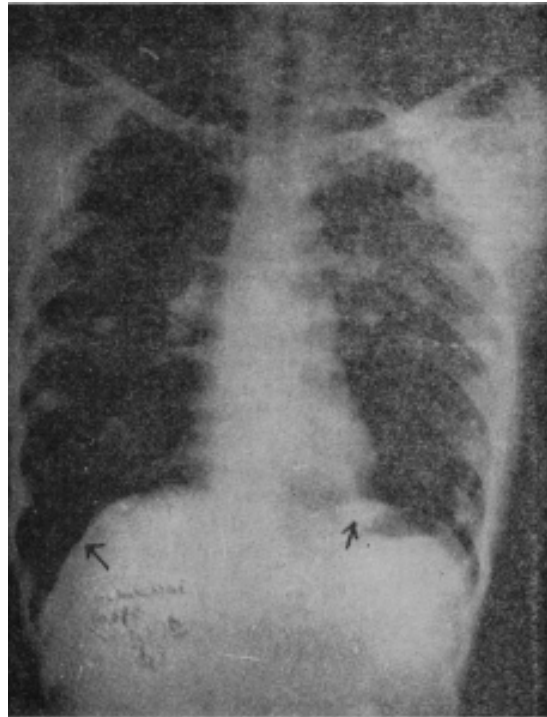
X-ray chest showing bilateral diaphragmatic pleural calcification. (Arrows). In addition, pulmonary and mediastinal calcification is also seen.
